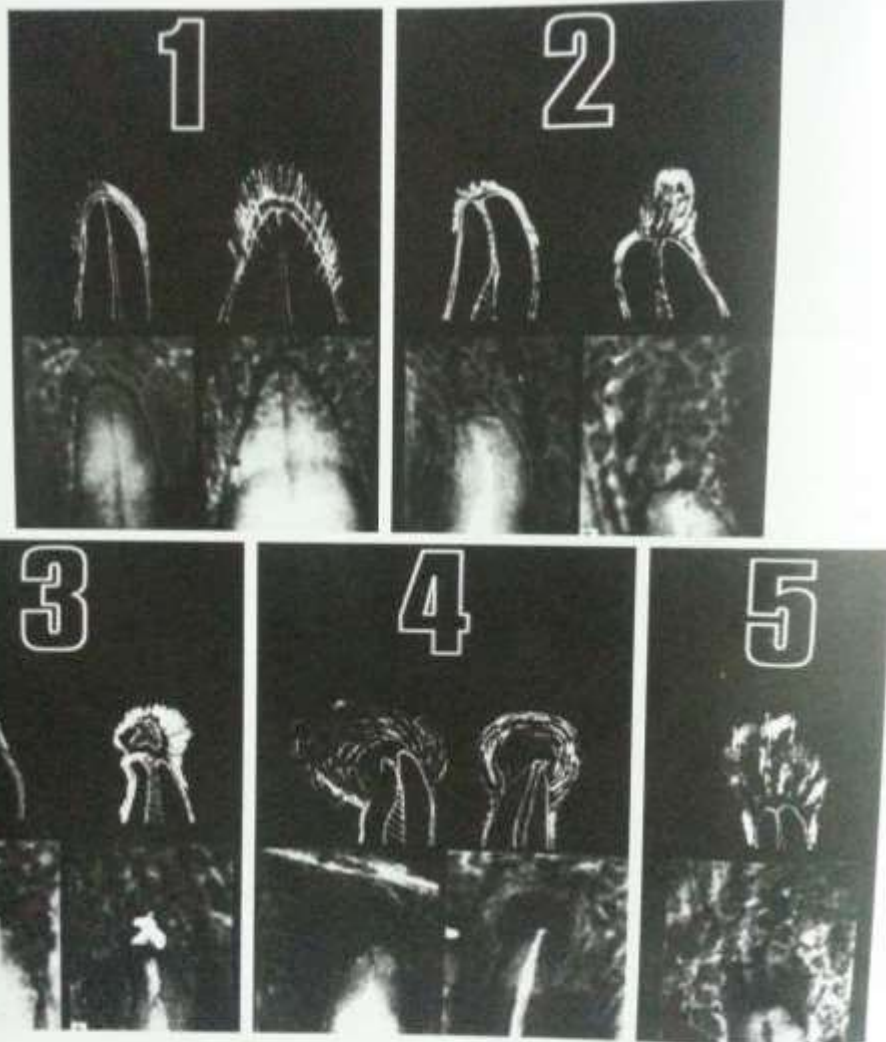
The periapical index^{6,7}
